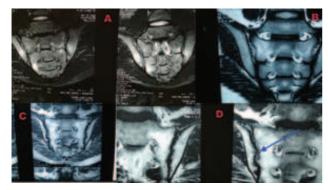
MRI scan of pelvis of: A: elder son (15-year-old) showing active sacroillitis in STIR image; B: younger son (12-year-old) showing early sacroillitis; C and D: grandfather (72-year-old) showing some bone marrow oedema with partial sclerosis of SI joints (blue arrow).
